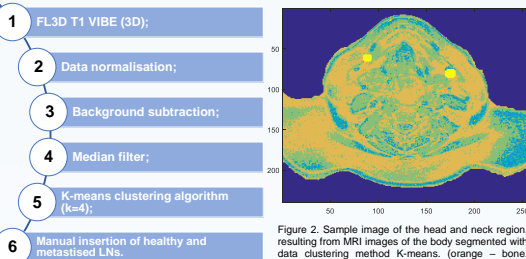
Sample image of the head and neck region, resulting from MRI images of the body segmented with data clustering method K-means. (orange – bone, green – muscle, blue – heterogeneous tissue, yellow – LNs.
